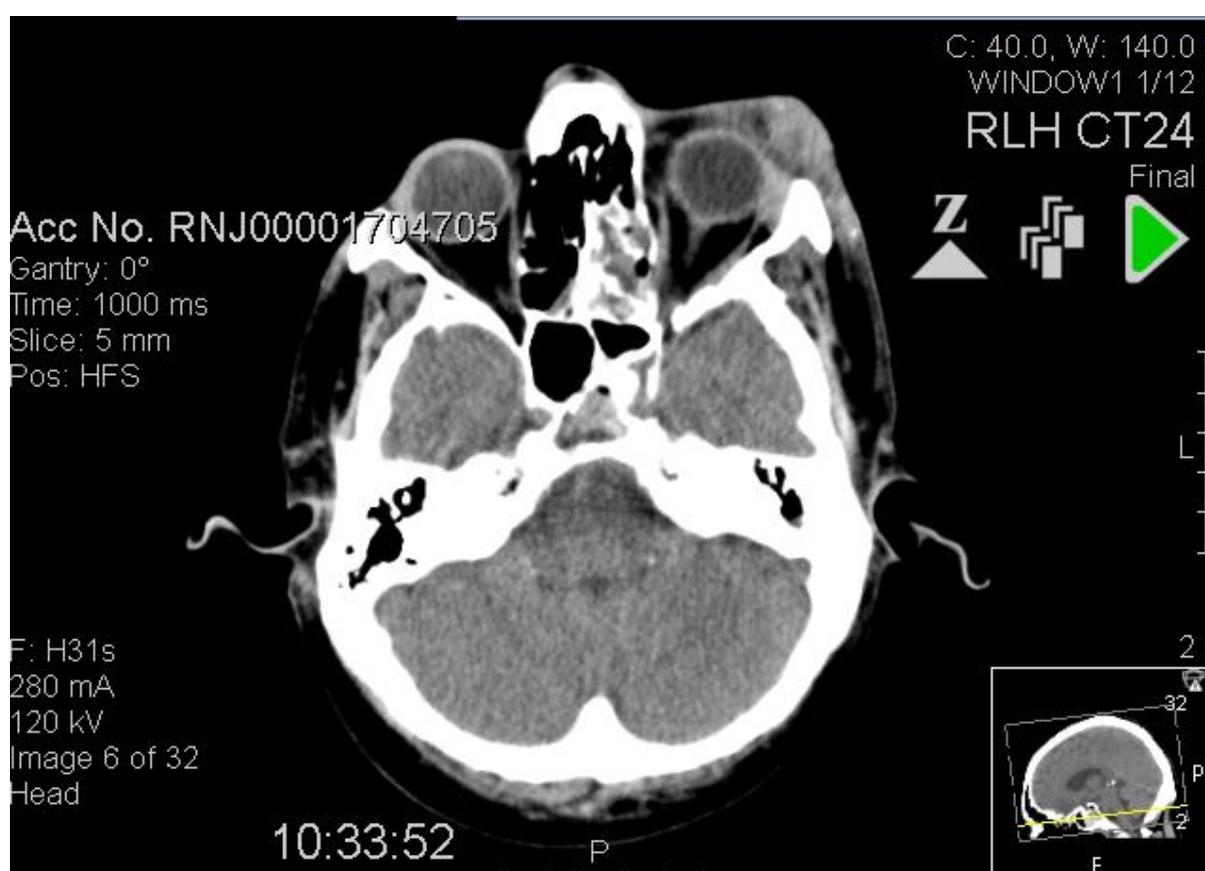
CT head showing fractures
